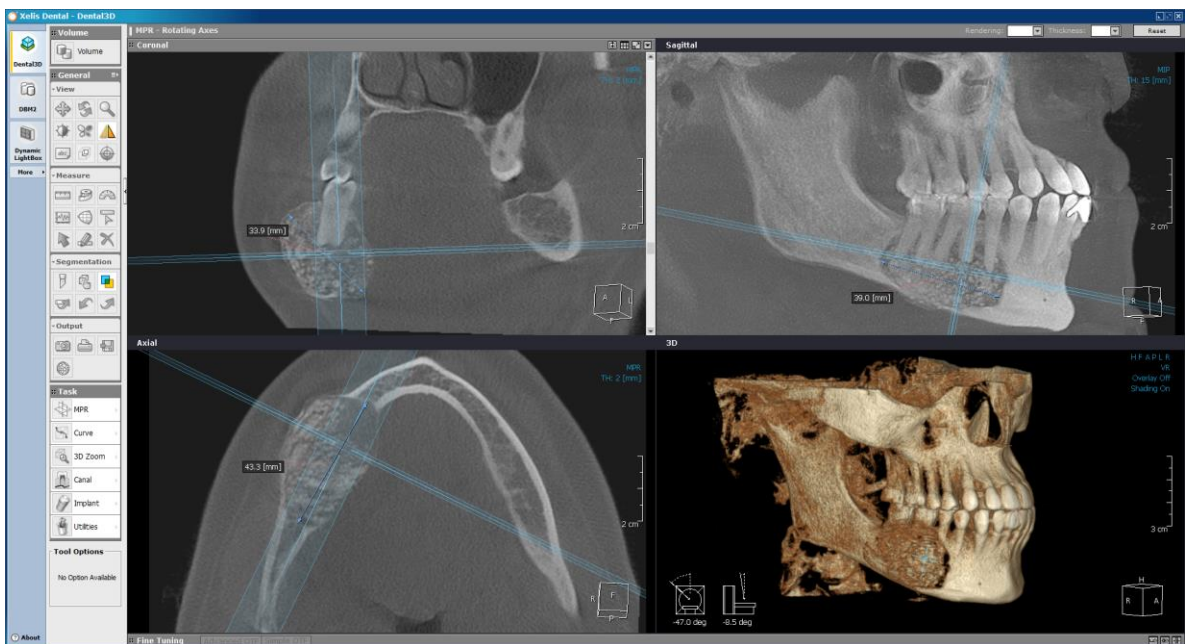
Initial CBCT (MPR/Rotating Axis view with 3-D rendering).
